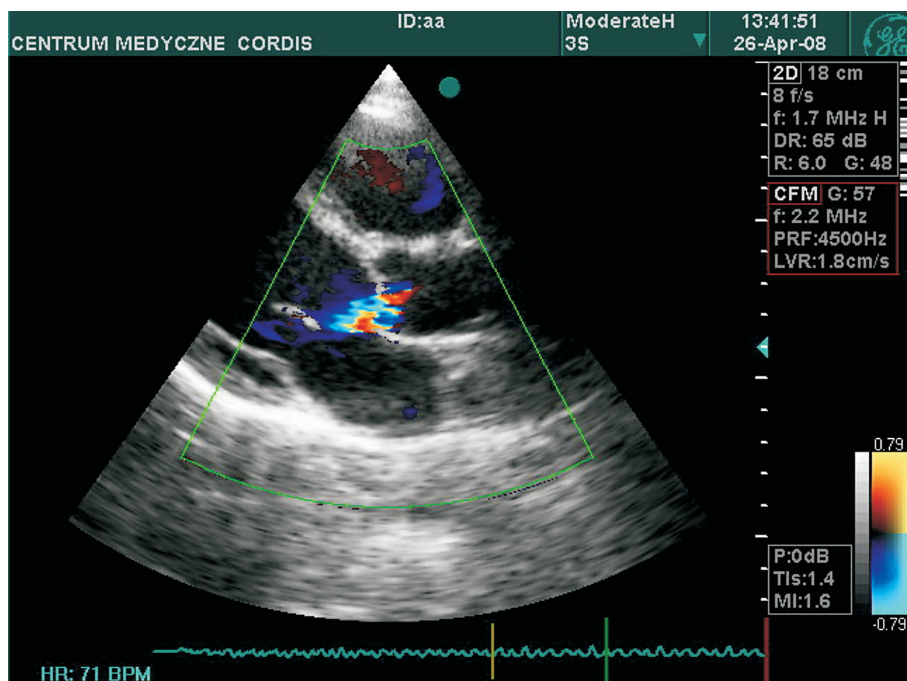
Echocardiography. Aortic valve stenosis (AI)
